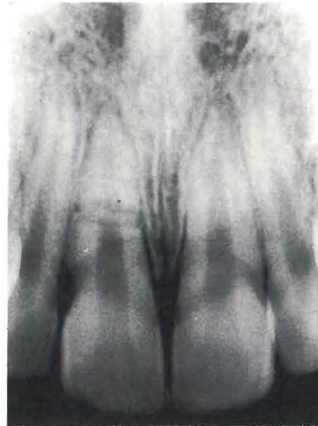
A twelve-year-old girl with a root fracture in the middle third of her maxillary right permanent central incisor (11). The radiograph was taken immediately after the accident.
